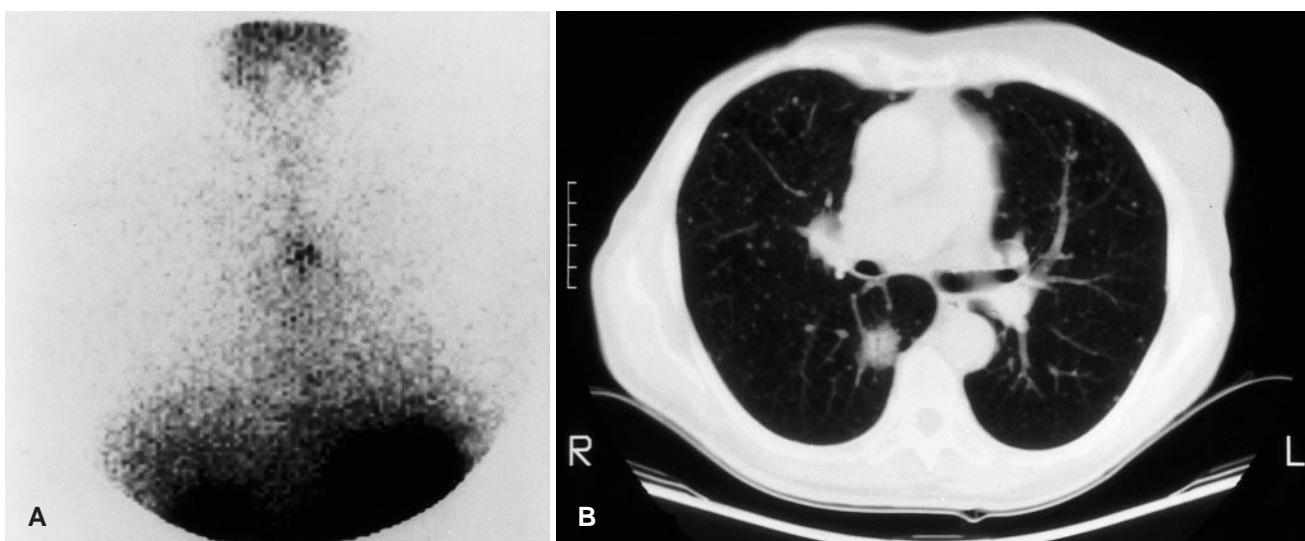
Patient 10. Focal increased uptake of radioiodine is seen on the 7-day post-therapy scan acquired of the anterior neck and chest in this 85-year-old patient (A). No accumulation of iodine is seen within the multiple pulmonary metastases visible on the CT scan (B)
